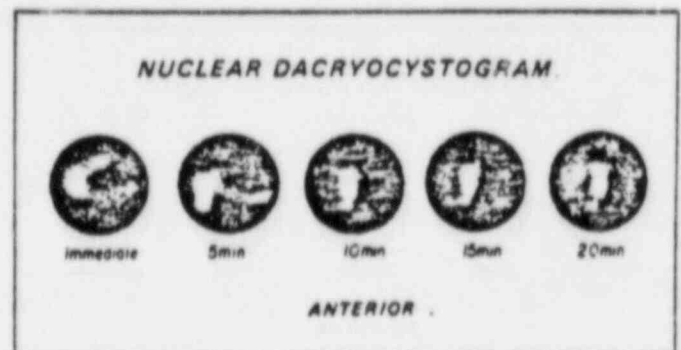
Sequential scintigrams of left eye showing normal drainage of radioactive tear. One can visualize the sac in the immediate scan, and the proximal duct in 5-min scan. At 10-min scan, the radioactivity is seen in the inferior meatus of the nose.
